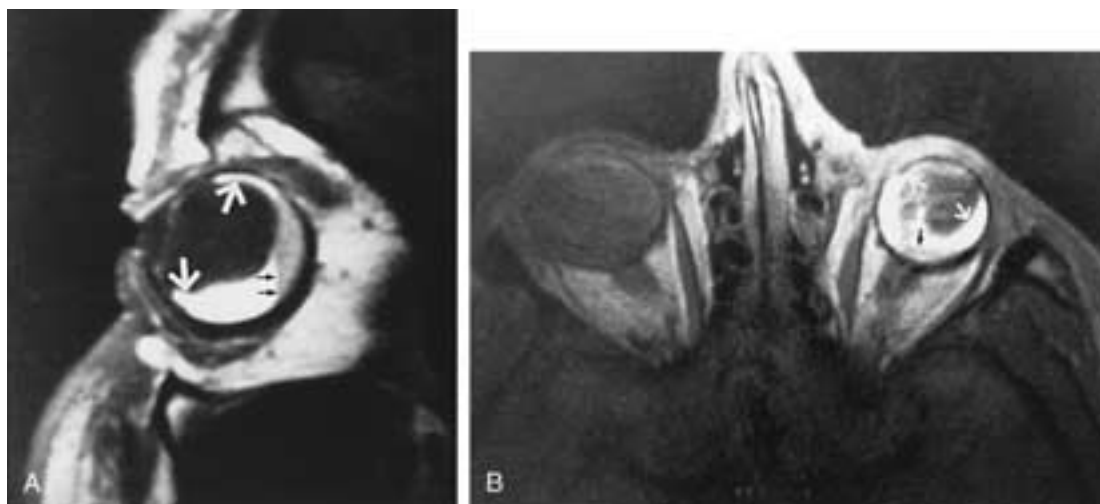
Retinal detachment. A, Sagittal T1-weighted sagittal MR image shows the leaves of a detached retina (*white arrows*). Subretinal fluid is hyperintense because of either exudate or chronic hemorrhage. Note the layered fluid (*black arrows*) caused by recent hemorrhage. B, Axial PW axial MR image shows leaves of a detached retina (*white arrows*) and layered recent hemorrhage (*black arrow*).
